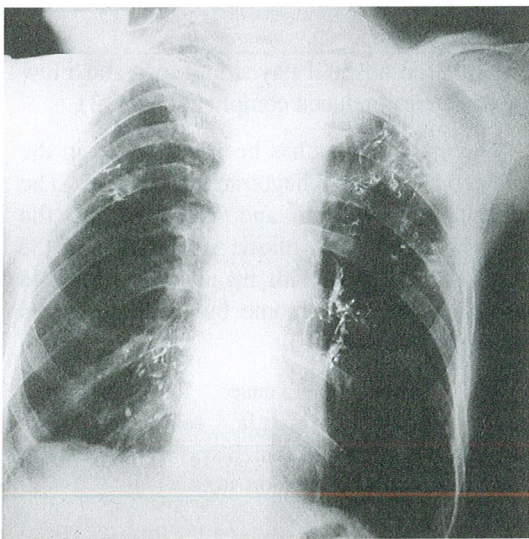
Chest X-ray showing the bronchogram before the stent replacement.
